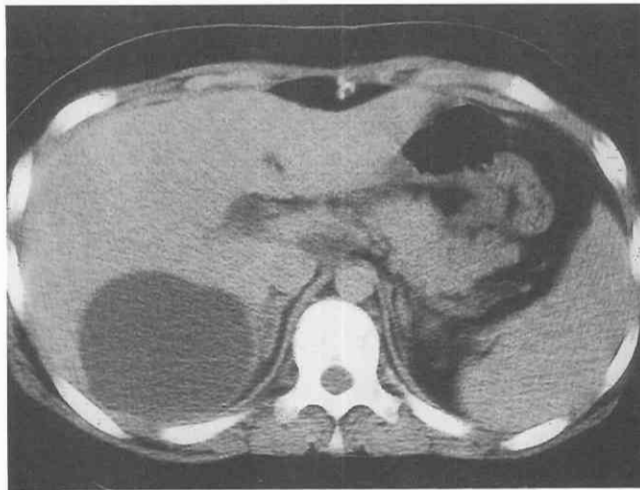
Extrapaneatic pseudocyst. CT scan through the upper abdomen in a patient with acute pancreatitis demonstrates an intraperitoneal pseudocyst posterior to the right lobe of the liver.
